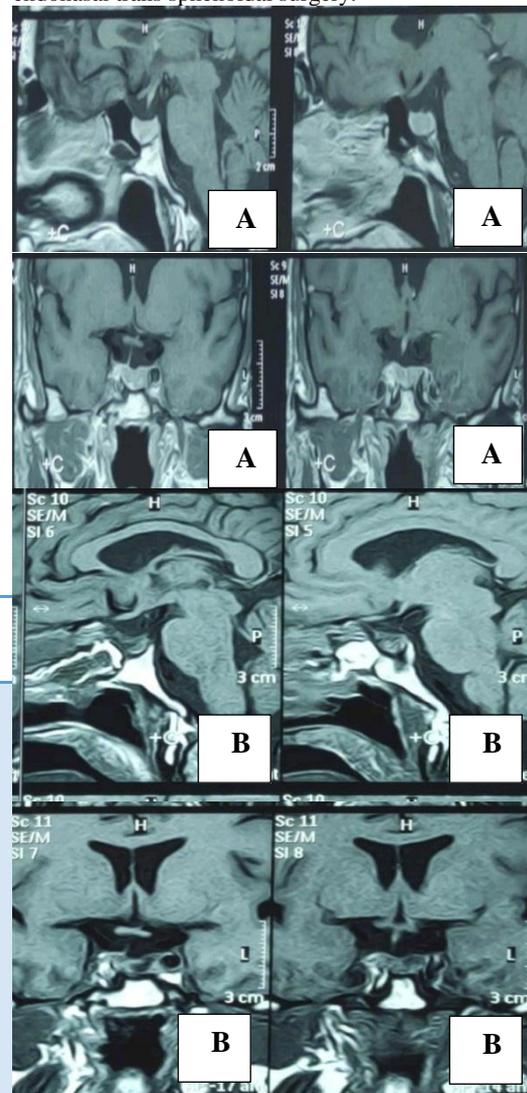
(A) Preoperative, sagittal and coronal contrast-enhanced T1-weighted MR images of a case of GH
